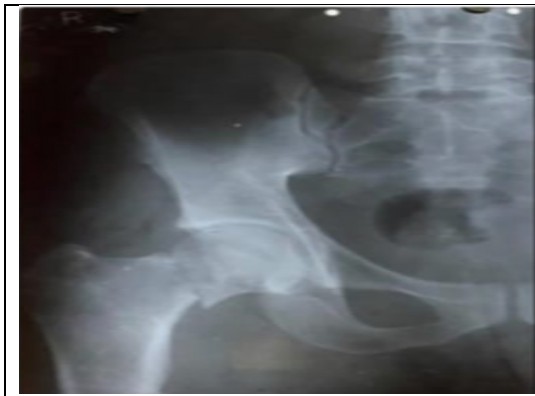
Preoperative anteroposterior radiograph of a 30-year-old male femoral neck fracture.
